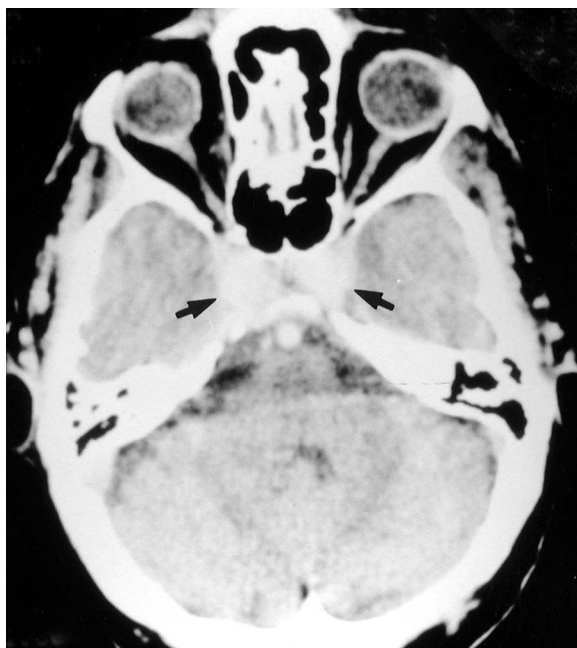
Axial contrast enhanced CT scan shows bilateral parasellar hyperdense lesions (arrows).
